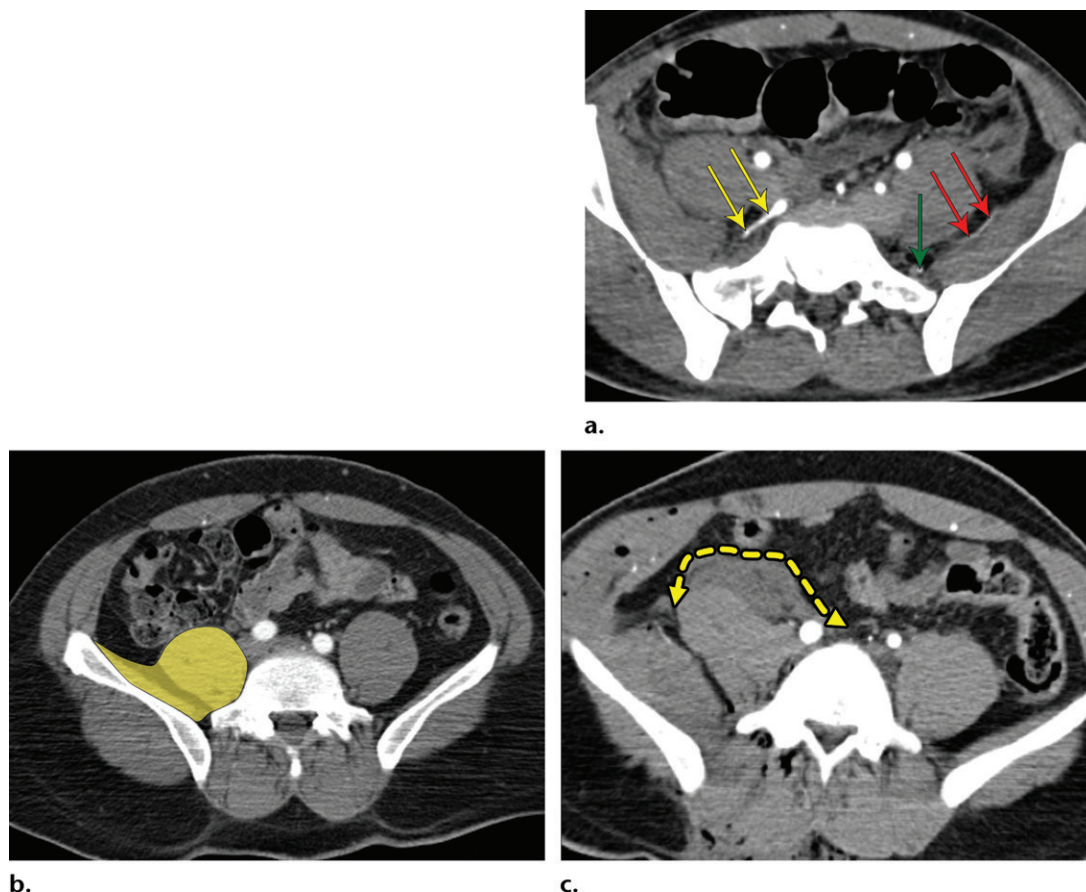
Iliolumbar artery in three patients. (a) Axial CT angiogram in a 35-year-old man shows the right iliolumbar artery (yellow arrows) arising from the posterior division of the internal iliac artery and following a horizontal outward trajectory anterior to the sacral ala. It bifurcates at the pelvic inlet level into the iliac (red arrows) and lumbar (green arrow) branches. The iliac artery is seen anterior to the iliacus muscle, and the lumbar artery runs vertically anterior to the sacral ala (left side). (b) Axial CT image in a 25-year-old man at the level of the L5 vertebra shows the vascular territory of the iliolumbar artery (yellow area). (c) Axial CT image in a 32-year-old man shows the iliolumbar artery and a corresponding pelvic intramuscular hematoma in the iliopsoas muscle (dashed line).
